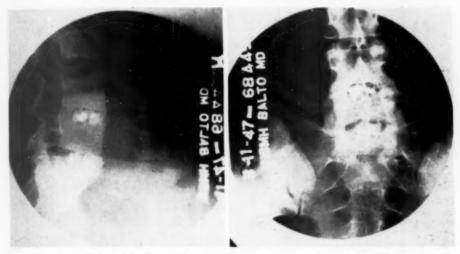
(b) (Left) AP X-ray for progress 5 mos. postoperative. Fusion present.
